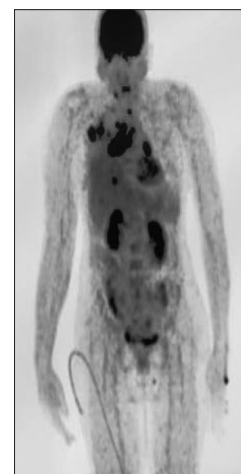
18F-FDG Whole body PET-CT scan with hyper-metabolic regions showing uptake of the tracer in the supra-hilar region of right lung, few mediastinal & axillary lymph nodes and in the left frontal lobe of the brain
